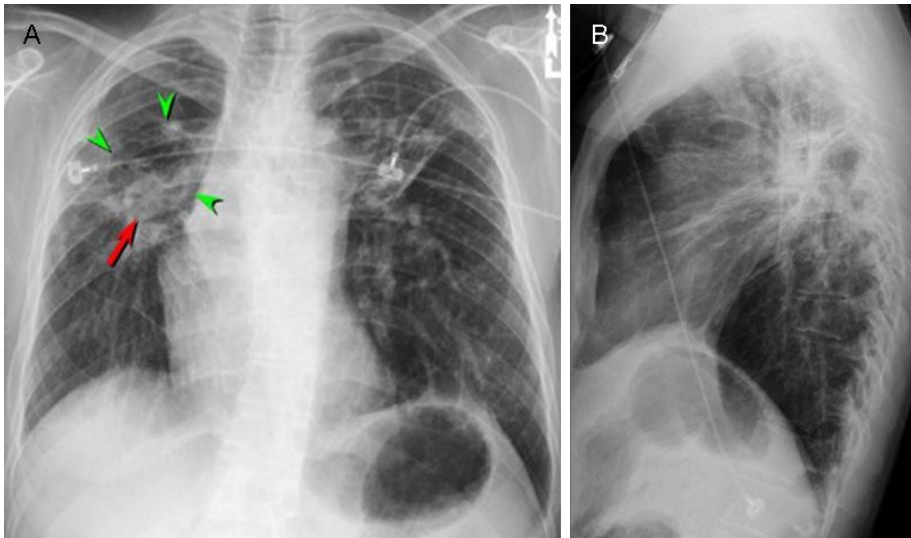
Frontal and lateral chest radiograph
